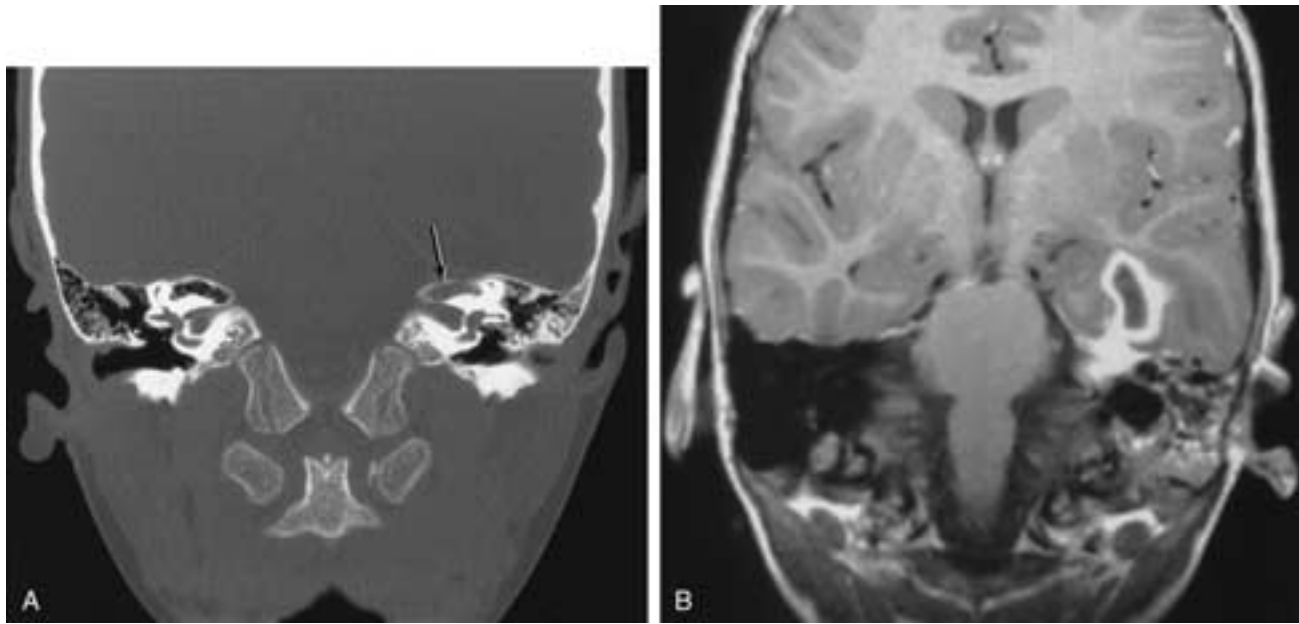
Petrous apicitis with intracranial abscess. A, Coronal CT image shows opacification of the left petrous apex with cortical erosion (*arrow*). B, T1-weighted, contrast-enhanced MR image reveals enhancement of the petrous apex and an adjacent temporal lobe abscess.
